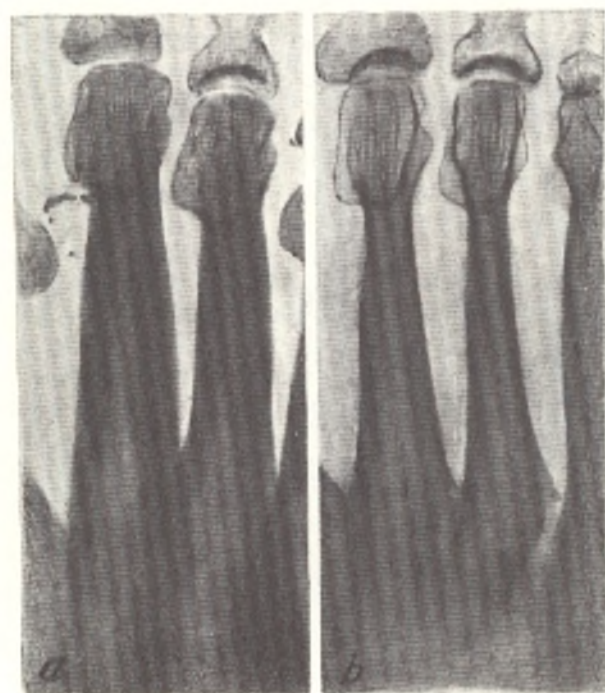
Radiographs of the metatarsal bones of a female ballet-dancer (a) and a person who works sitting (b)
